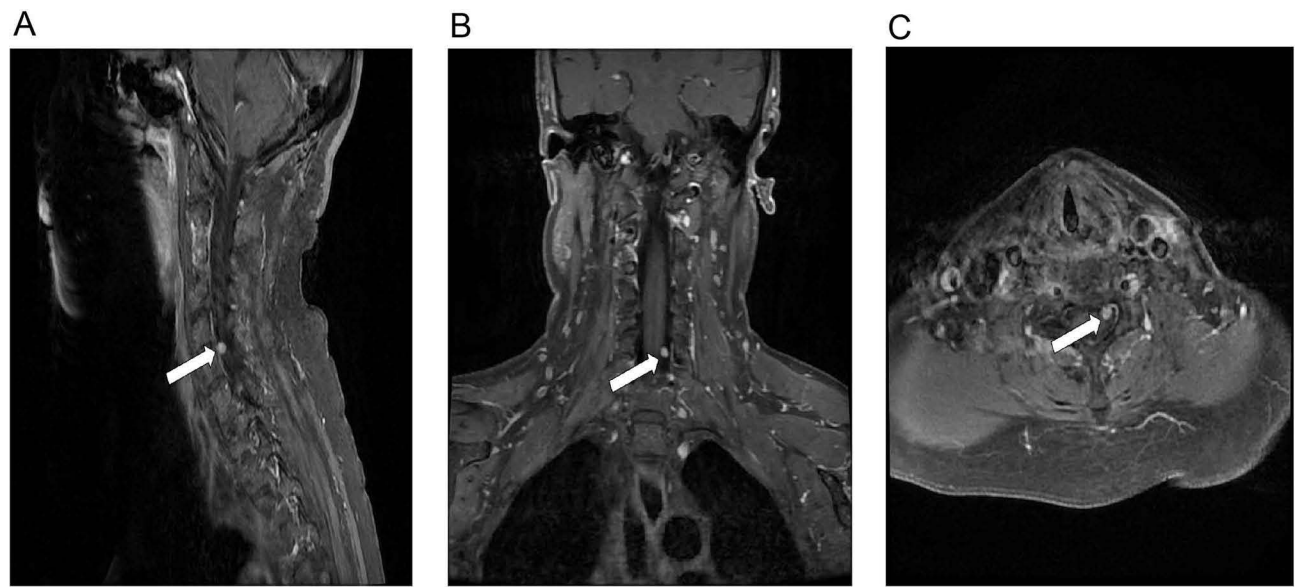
Cervical spine MRI scan of syphilitic spinal cord gumma in T1 hyperintensity. (A) Sagittal T1-postgadolinium images reveal nodular leptomeningeal enhancement (arrow). (B) Coronal T1-postgadolinium (arrow). (C) Axial T1-postgadolinium image (arrow).
